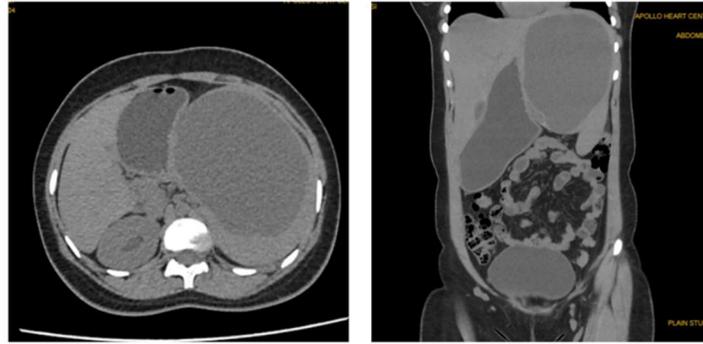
CT SCAN -axial and coronal plane showing splenic cyst
